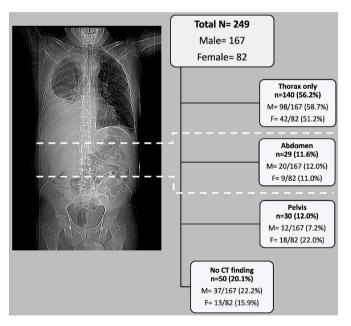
Coronal CT scout image depicting anatomical landmarks for abdominal and pelvic portions (abdomen was categorised as between the inferior point of the costophrenic recess to the superior aspect of the iliac crests, while the pelvic portion was defined as anything inferior to the iliac crests) with proportion of patients with additional significant CT findings by anatomical region.
